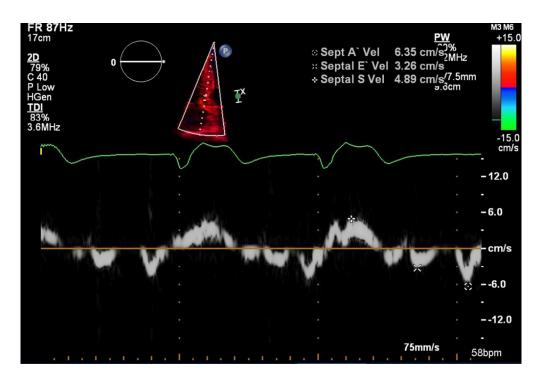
(b): Tissue Doppler echocardiogram demonstrating reduction in early myocardial relaxation at the annulus. In conjunction with the mitral early filling, this value contributes to calculation of E/e' that reflects impaired myocardial compliance.
